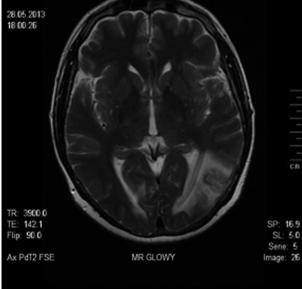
Patient's MRI performed on admission to the hospital. Visible white matter oedema in the occipital white matter.
